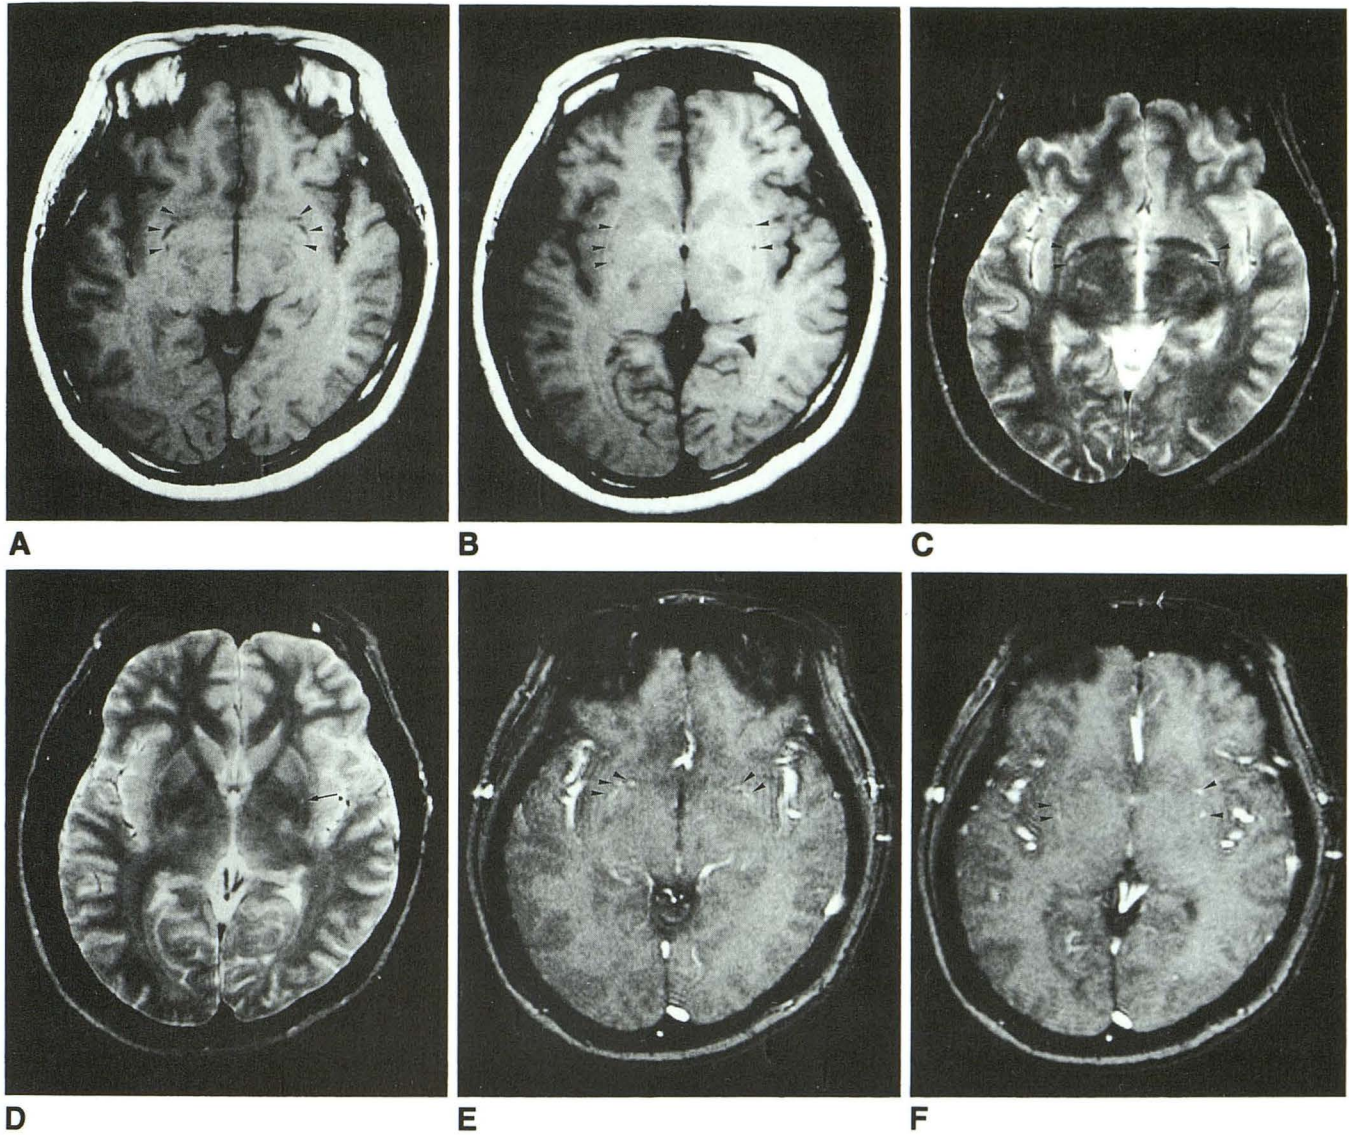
Spin-echo and FLASH images in a 30-year-old woman. On T1-weighted images (630/15/2) several Virchow-Robin spaces of low-intensity (*arrowheads*) are seen around the anterior commissure (A) and in the basal ganglia of both sides (B). On T2-weighted images (2500/90/1) comparable foci of CSF (high)-intensity are seen around the anterior commissure (*arrows*) (C) and in the left basal ganglia (*arrow*), but not in the right basal ganglia (D). Most Virchow-Robin spaces are delineated as high intensity on FLASH sequence images (80/7/1) because of flow of lenticulostriate arteries (*arrowheads*) (E, F).
